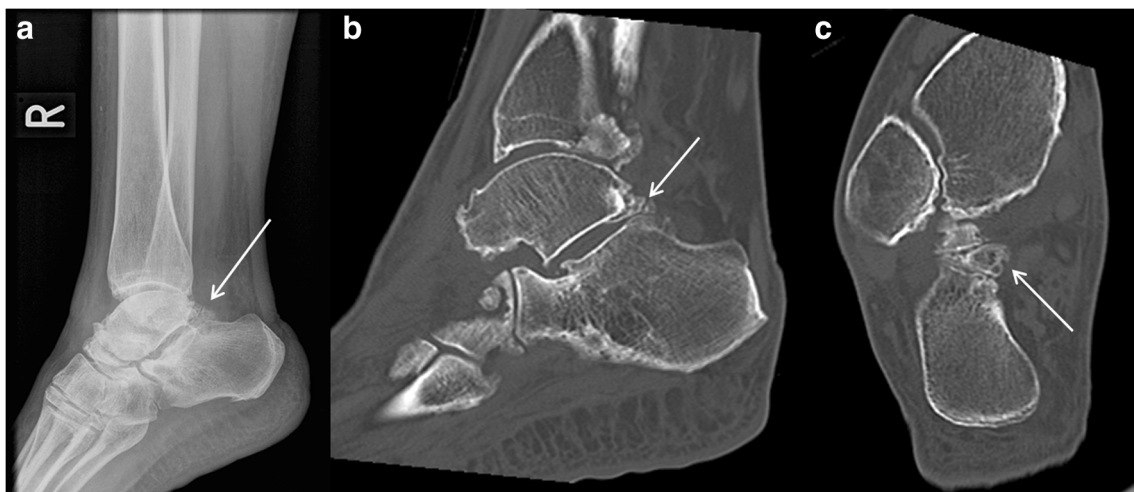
Lateral radiograph of the right ankle (a) shows a bipartite os trigonum with well-corticated margins (arrows). Sagittal (b) and axial (c) CT images of the ankle confirm the bipartite variant (arrow)
